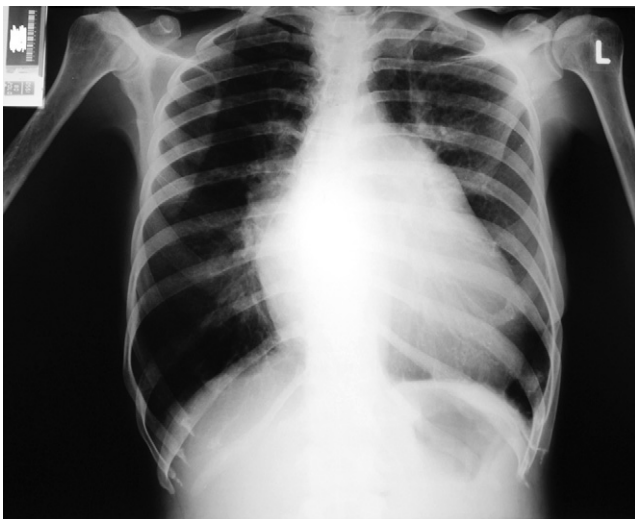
Preoperative postero-anterior projection X-ray.
